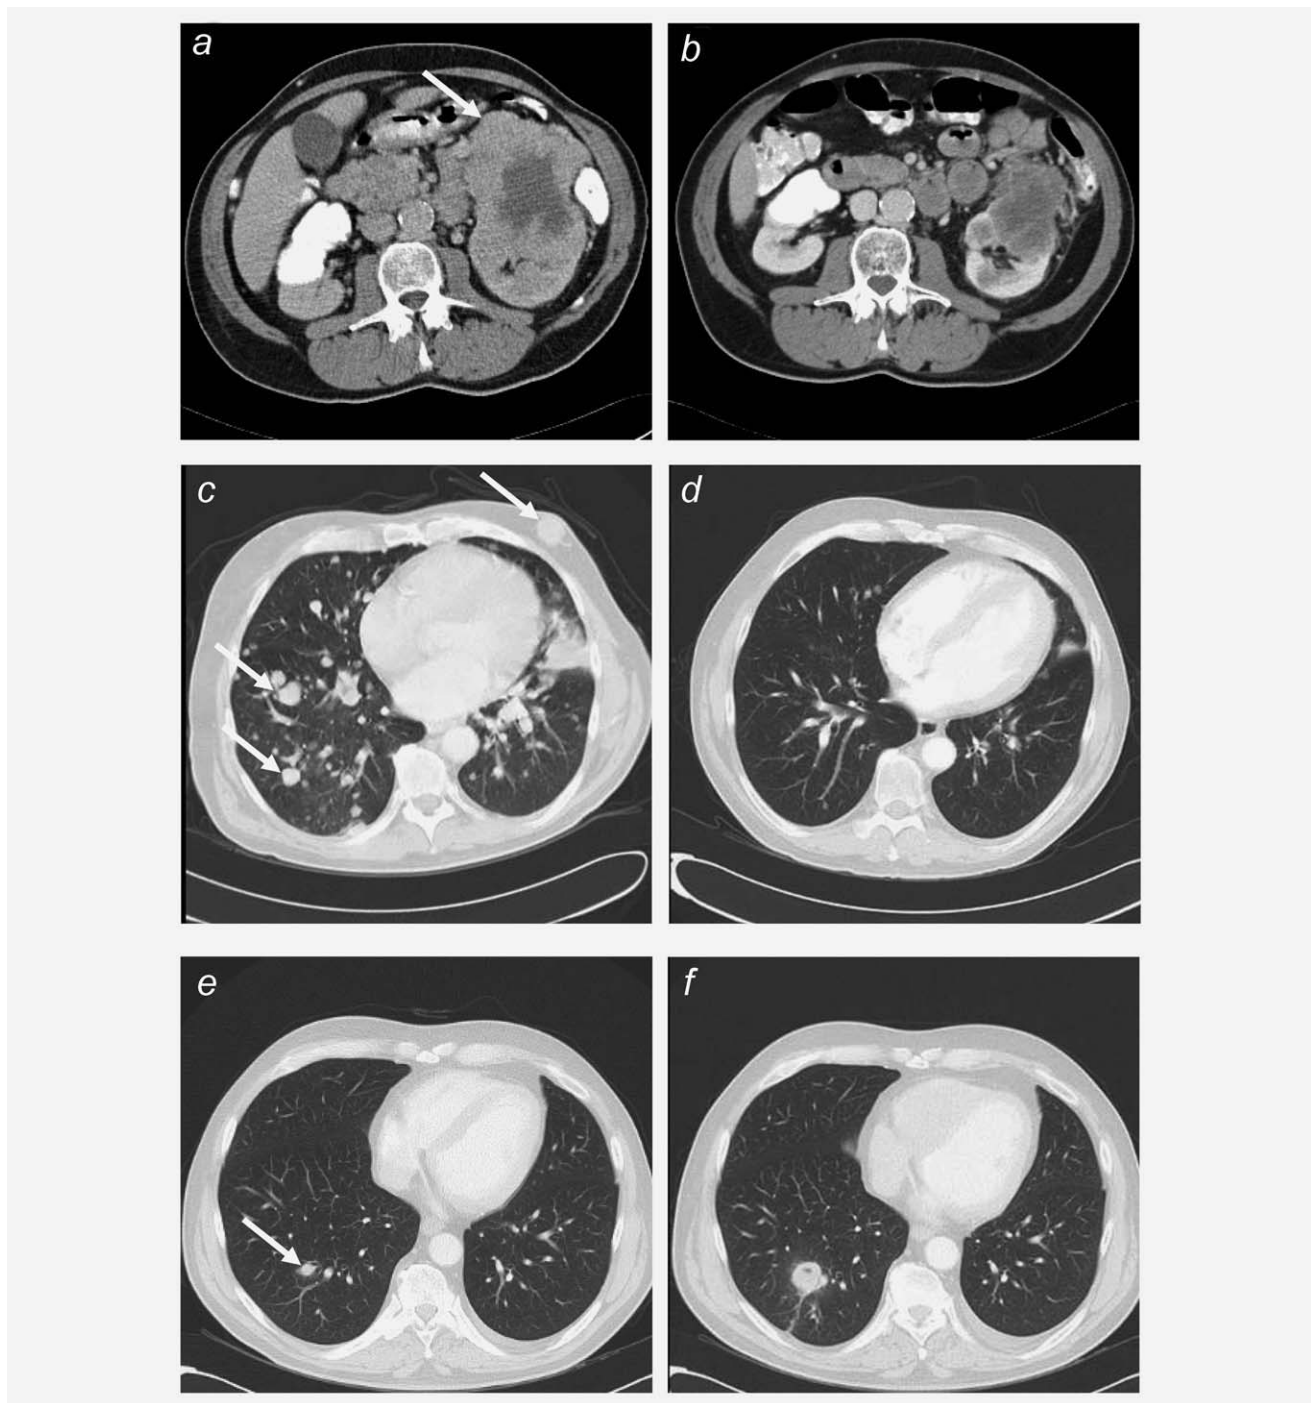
Examples of CT images in two patients with mRCC treated with sunitinib. (a–d) A responding patient with a primary tumor *in situ* (a, arrow), multiple lung and subcutaneous metastases (c, arrows) at baseline and at first evaluation during sunitinib (b, d). The patient showed a 71% decrease in circulating Ang-2 on C1D28 and a 33% decrease in total tumor burden at first evaluation. (e, f) A nonresponding patient with lung metastases at baseline (e, arrow) and at first evaluation during sunitinib (f). The patient showed a 92% increase in circulating Ang-2 on C1D28 and a 49% increase in total tumor burden at first evaluation.
